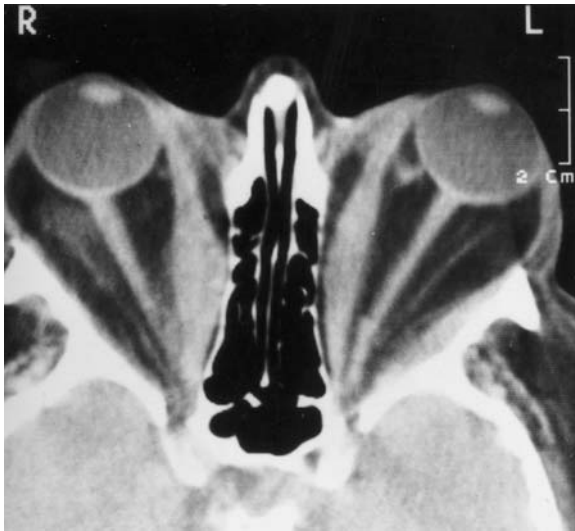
A 49-year-old woman with persistent Graves' disease. Axial CT shows severe thickening of the medial rectus muscles, more pronounced on the right side, and marked bilateral pressure on the lamina papyracea. Note substantial hypertrophy of the orbital fat, responsible for extreme exophthalmos and stretching of both optic nerves. (With permission of MÜLLER-FORELL and LIEB 1995b)
